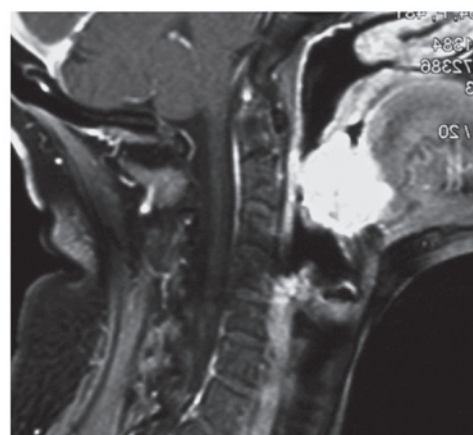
Magnetic resonance imaging revealed a 41x35x31-mm soft tissue mass that extended from the anterior wall of the epiglottis to the base of the tongue, but did not affect the parapharyngeal space.
